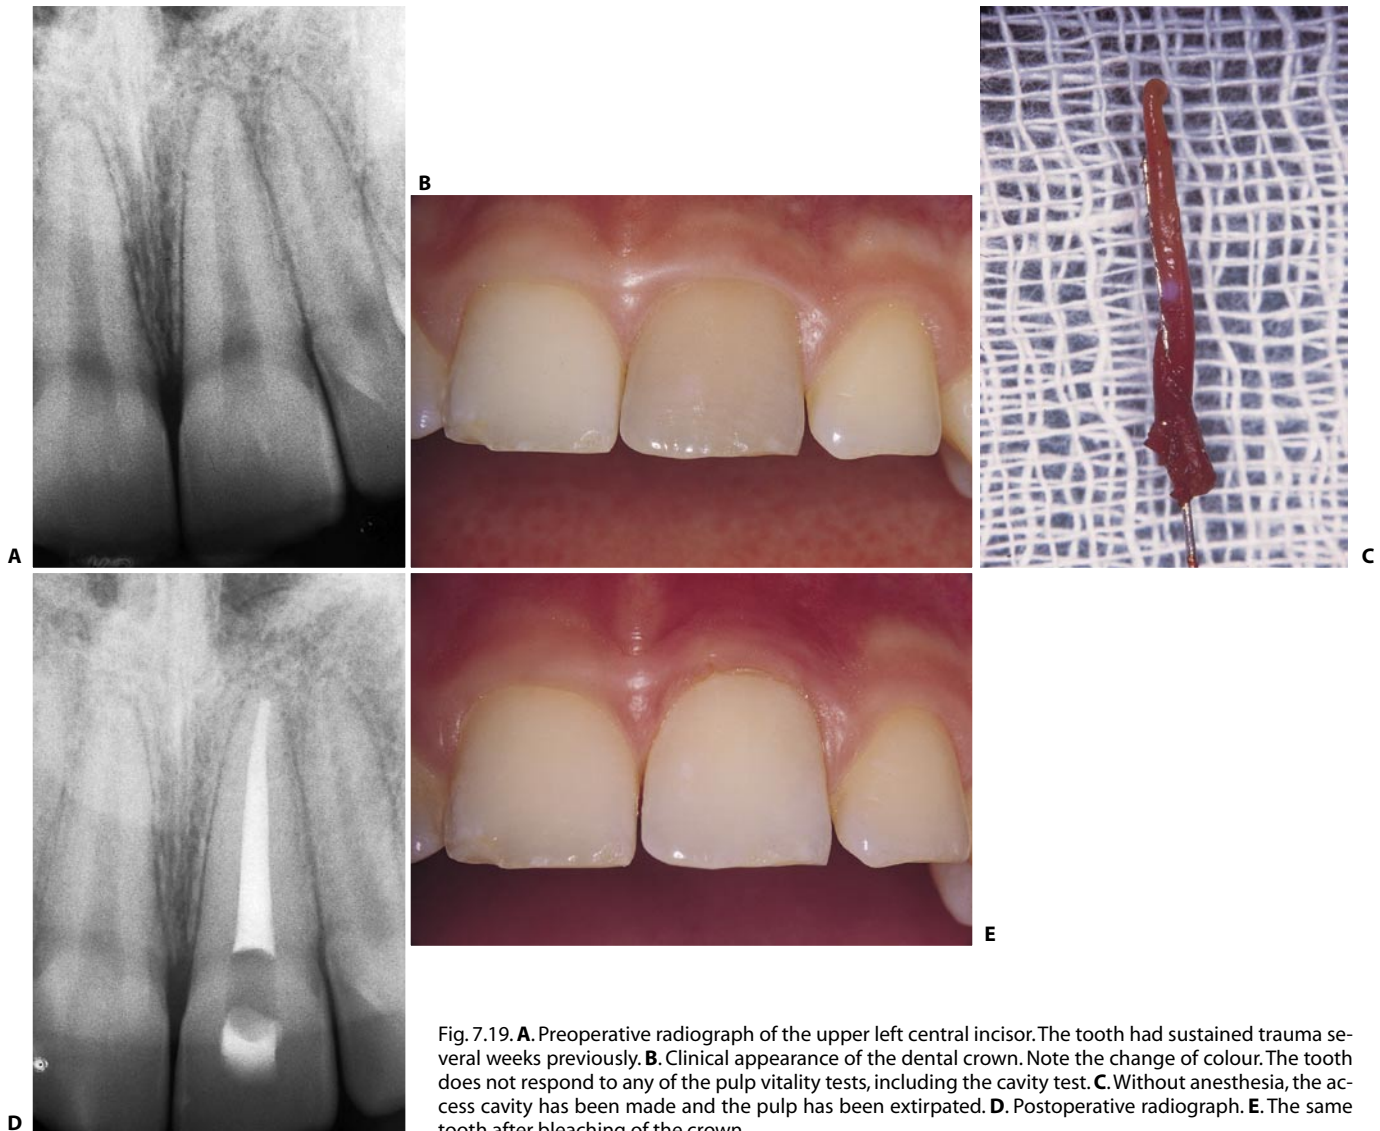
A. Preoperative radiograph of the upper left central incisor. The tooth had sustained trauma several weeks previously. B. Clinical appearance of the dental crown. Note the change of colour. The tooth does not respond to any of the pulp vitality tests, including the cavity test. C. Without anesthesia, the access cavity has been made and the pulp has been extirpated. D. Postoperative radiograph. E. The same tooth after bleaching of the crown.
